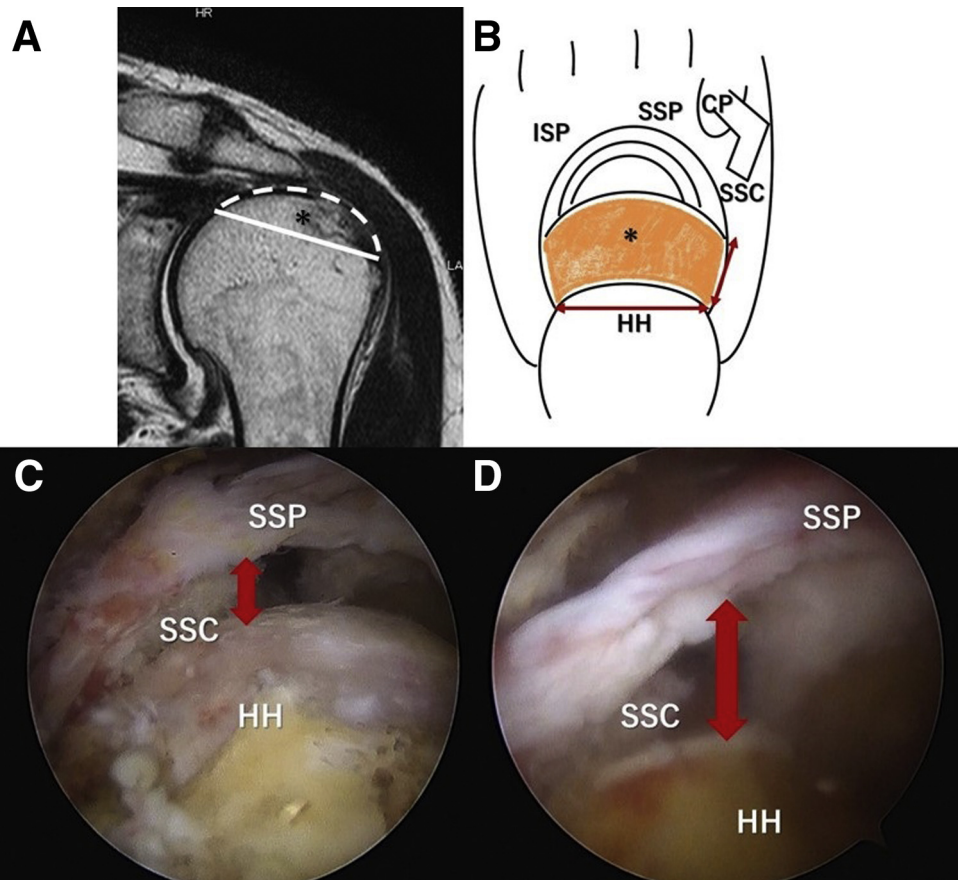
Depiction of the shaving area of the humeral head for extreme medialization. After shaving, improvement of the downward view of SSC. (A) Coronal T2-weighted magnetic resonance imaging of the shaving area of the left shoulder. (B) Shaving area of the right shoulder from the lateral view. (C) Before shaving view of the left shoulder from the posterolateral portal. (D) After shaving view of the left shoulder from the posterolateral portal. CP, coracoid process; HH, humeral head; ISP, infraspinatus; SSC, subscapularis; SSP, supraspinatus. An asterisk (*) denotes the shaving area.
